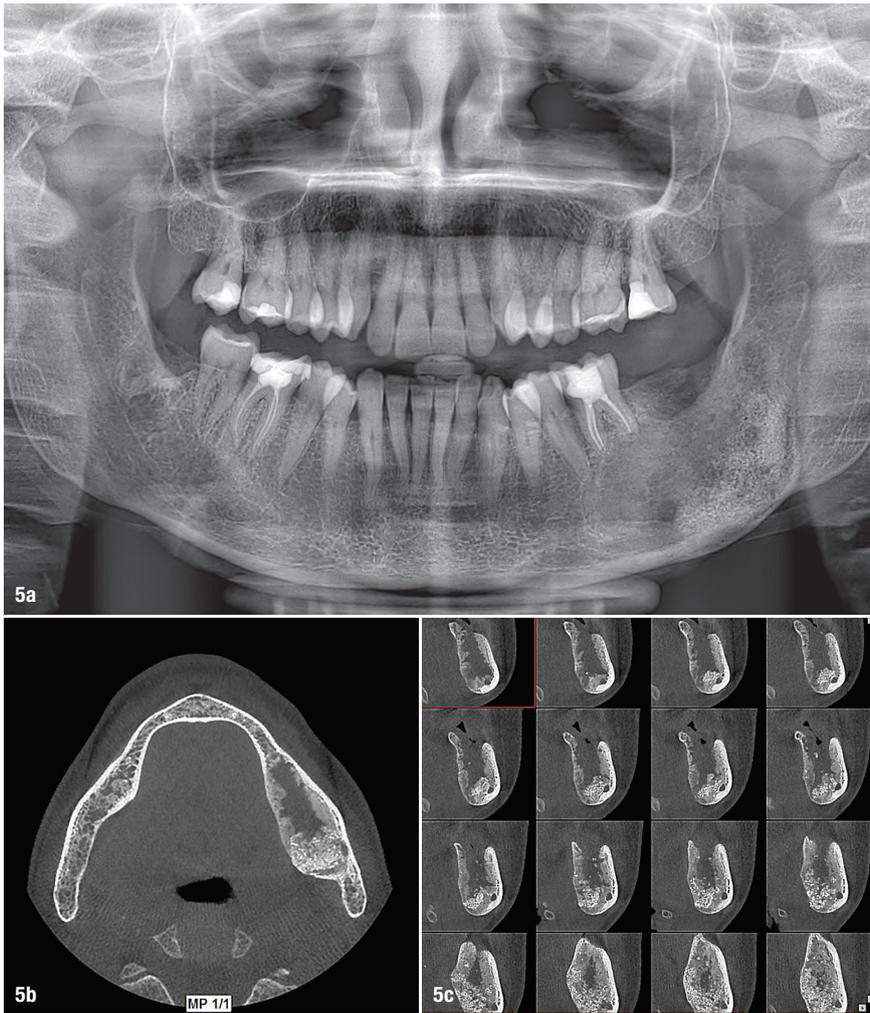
Final dental panoramic tomogram (a), final CT sagittal section (b), final CT cross section (c).
